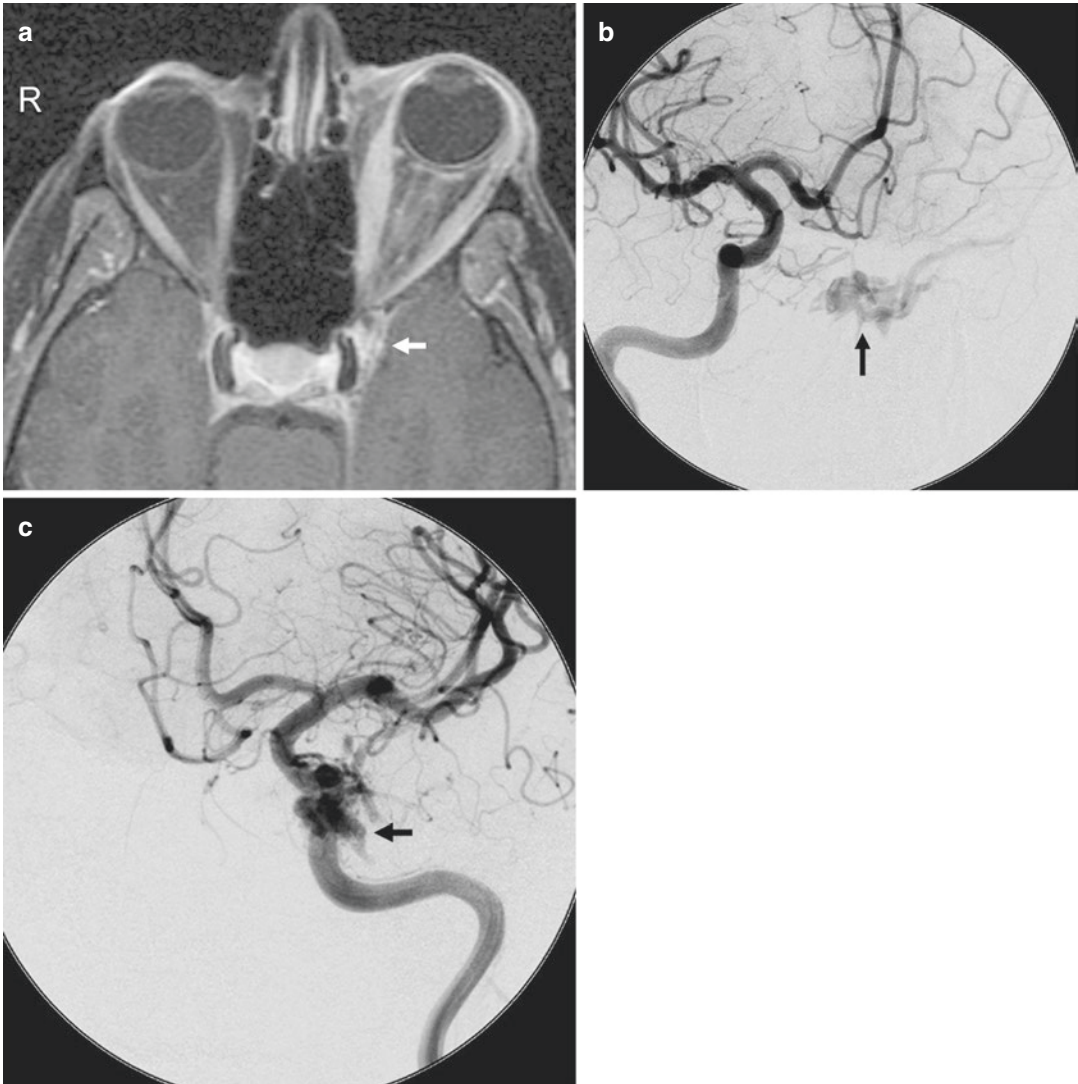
Left CCF. (a) Axial T1-weighted post-contrast with fat suppression image demonstrates left proptosis, enlargement of the left extraocular muscles, and slight asymmetric fullness of the left cavernous sinus. (b, c)
